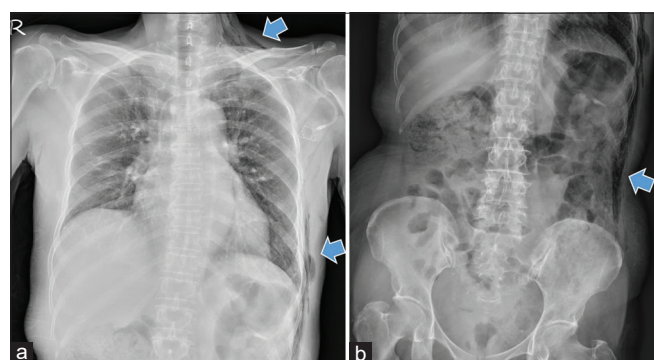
(a and b) Chest and plain abdominal radiography revealed subcutaneous emphysema (blue arrow) at the left lower neck and left chest wall extending to the left abdominal wall
